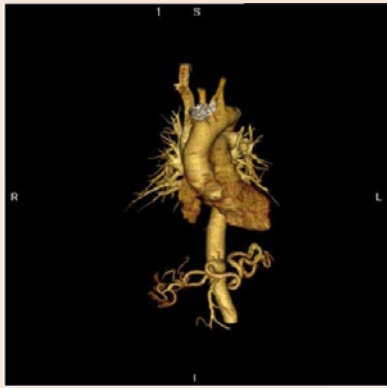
CT reconstruction of initial celiac artery aneurysm.
